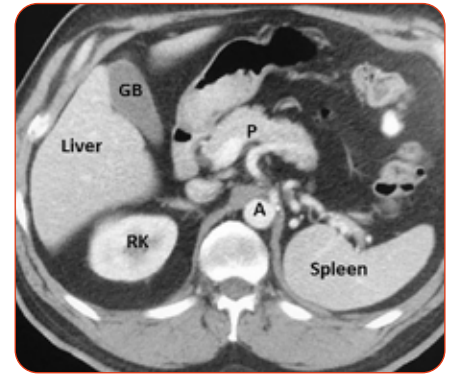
Axial enhanced CT scan showing left nephrectomy. The spleen is lying in the space previously occupied by the left kidney. RK = right kidney. GB = gallbladder. A = aorta. P = pancreas.
